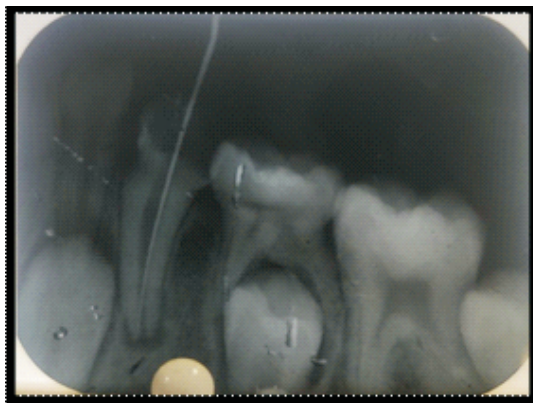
Periapical radiograph showing access cavity and determination of working length in the first visit
